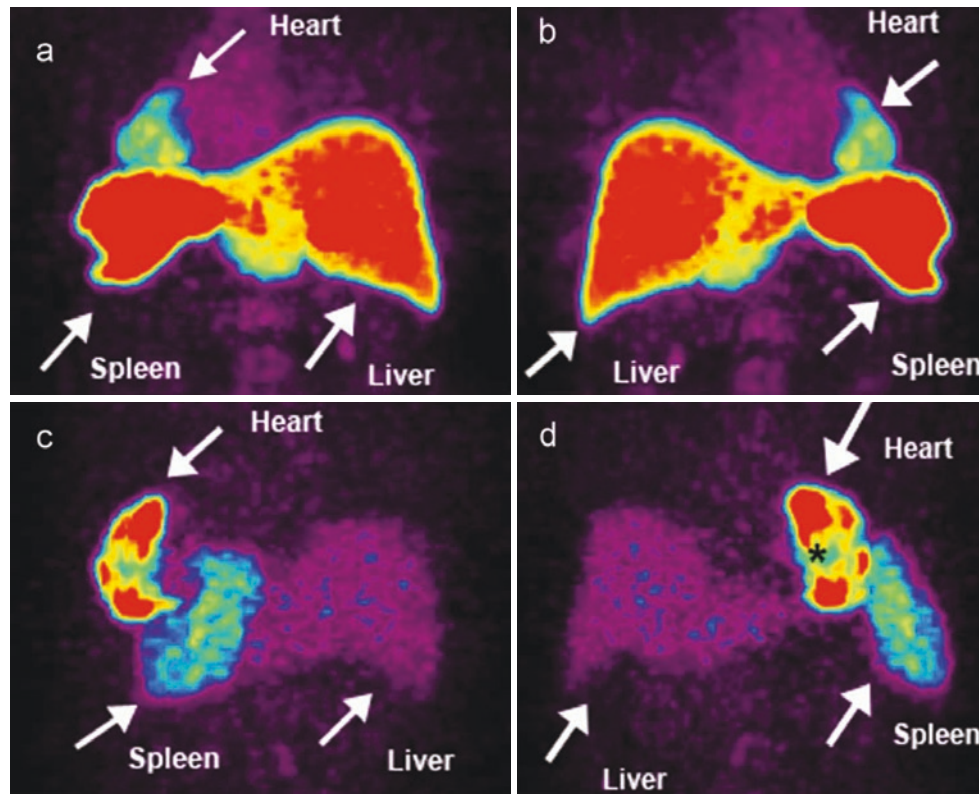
Myocardial homing and biodistribution of FDG-labeled bone marrow cells [45]. Shown are the left posterior oblique (a) and left anterior oblique (b) views of the chest and upper abdomen of the patient taken 65 minutes after the transfer of ^{18}F -FDG-labeled, unselected bone marrow cells into the left circumflex coronary artery, and the left posterior oblique (c) and left anterior oblique (d) views of the chest and upper abdomen of another patient taken 70 minutes after the transfer of ^{18}F -FDG-labeled, CD34-enriched bone marrow cells into the left anterior descending coronary artery. In both patient examples, bone marrow cell homing is detectable in the heart (infarct center and border zone), liver, and spleen. CD34⁺ cell homing is most prominent in infarct border zone, but not infarct center (*asterisk*). Our current knowledge of the dynamics of intermediary metabolism remains fragmented and poorly
